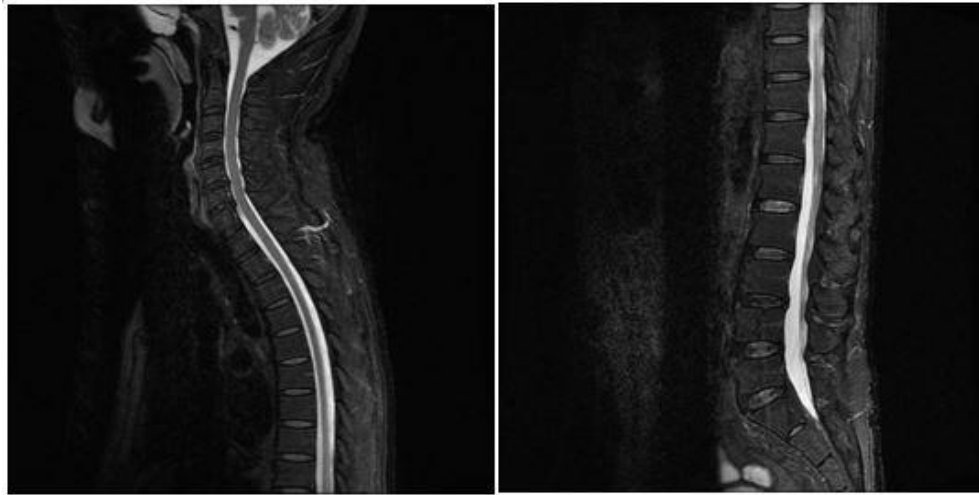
Sagittal T2-weighted images of the spine
